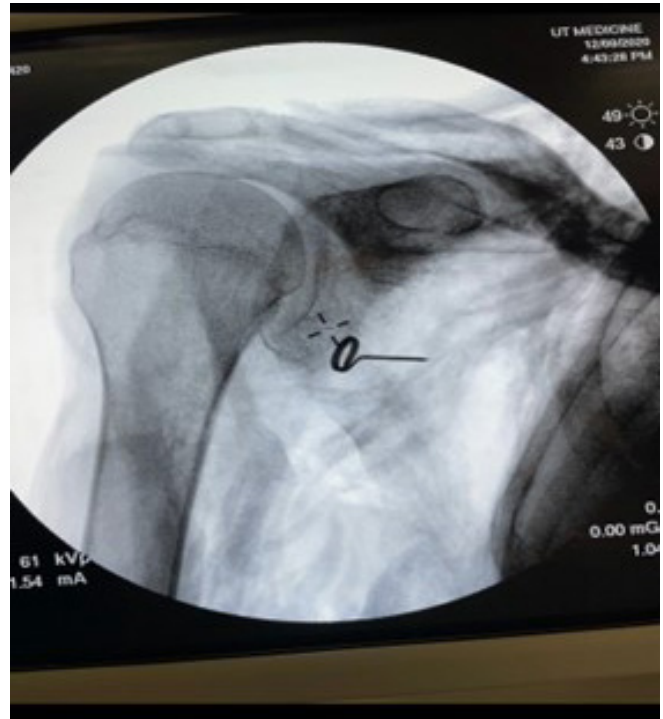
C-arm X-ray Image of the right shoulder with pinpoint identification of the upper subscapular nerve. A total of 12 shoulders (6 of the right shoulder, 6 of the left) were taken to provide radiographic insight into the location of the upper subscapular nerve.
